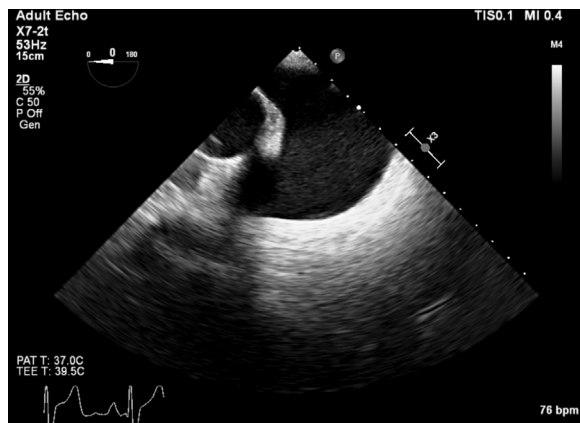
Modified midesophageal ascending aortic short-axis transesophageal echocardiography image.
